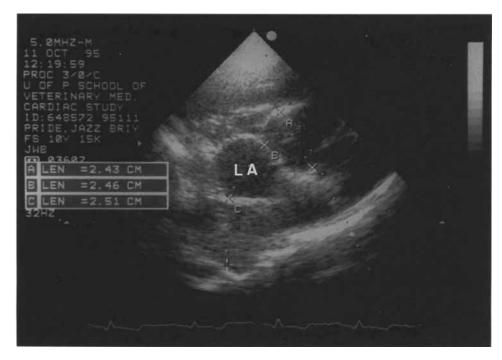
Two-dimensional echocardiogram 6 months after surgery. Right parasternal, short axis view. The left atrium (LA) above the mitral annulus is still free of tumor. The dimensions of the aorta (A), left atrium (B), and caudal atrial tumor mass (C) were nearly equal.
